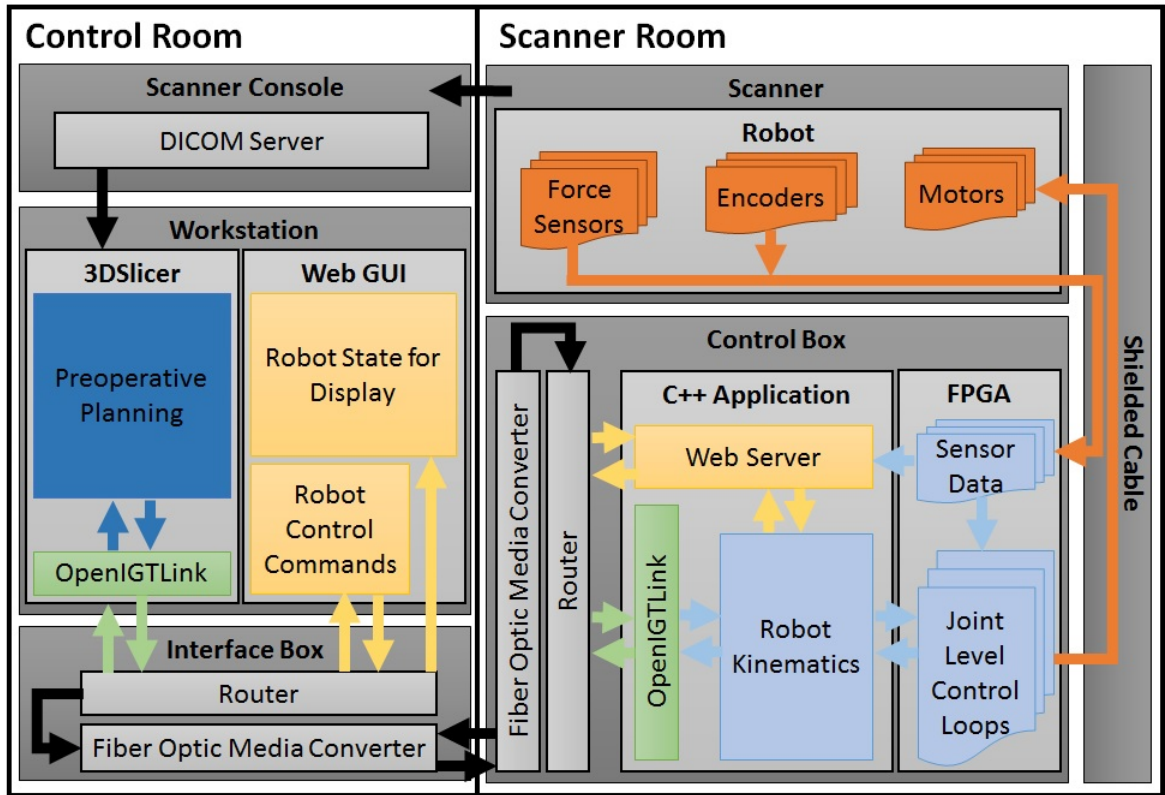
Software integration of the system into the clinical environment. In the control room the scanner console pushes DICOM images to the workstation running 3DSlicer navigation software and the web GUI for robot control. The web GUI both displays the robot state and allows for direct control of the robot in both joint and task space. The control box is located inside the scanner room and communicates to the workstation via a fiber optic cable through the scanner room wave guide. Surgical planning information is passed via OpenIGTLink while the web GUI interface communicates to a web server running on the control box. The robot is inside the scanner bore and the MR images arrive at the scanner console to be pushed to the workstation.
